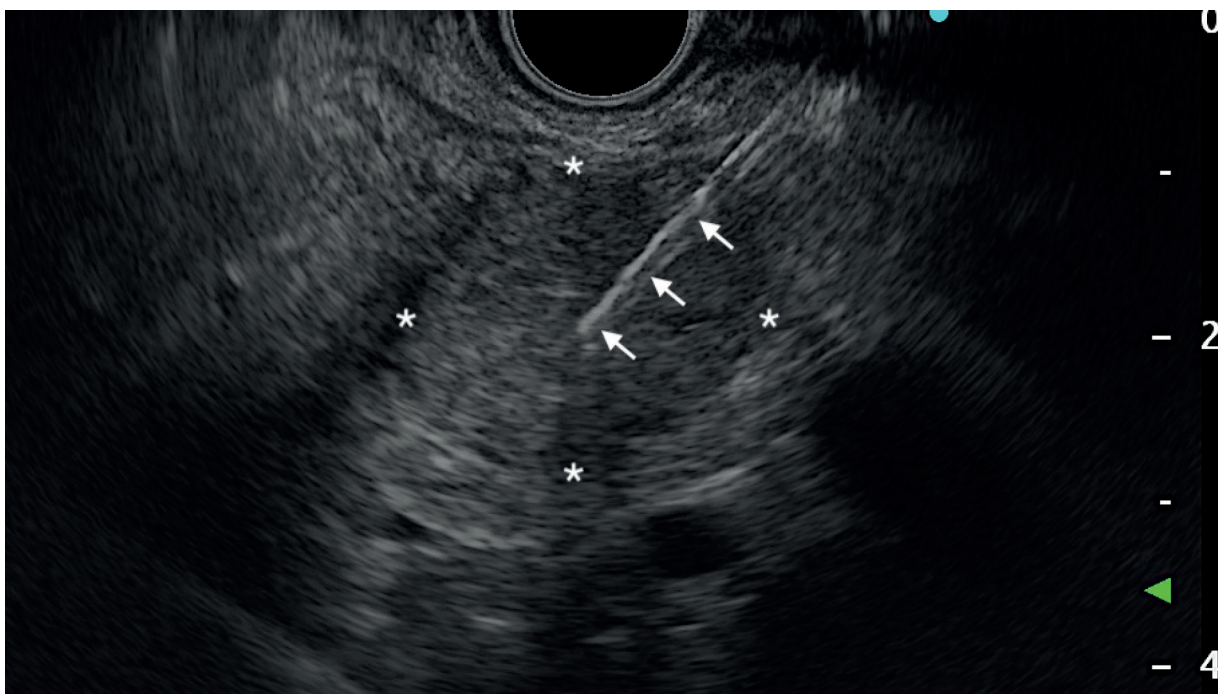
Endoscopic ultrasound (EUS) — biopsy needle (arrows) in 20 mm pancreatic lesion (asterisks)
